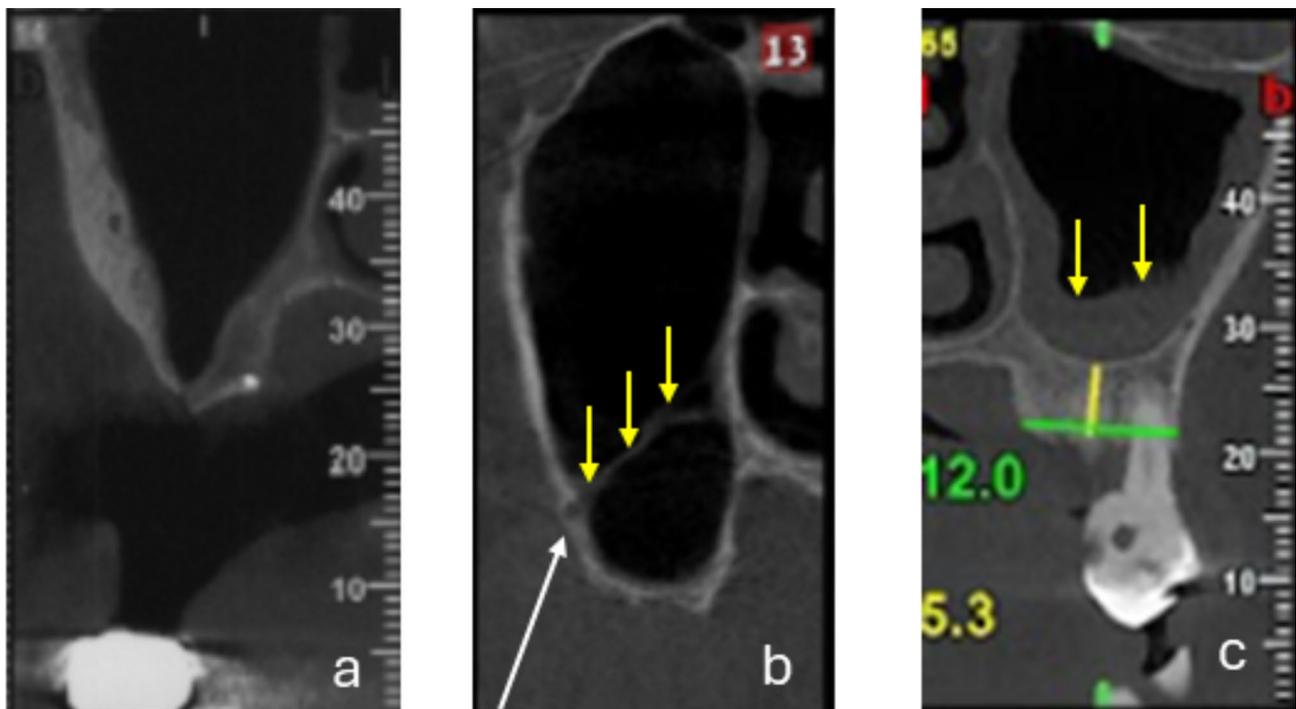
Paraxial CBCT radiographic examinations: a: Triangular shape sinus. b: Oval shape sinus demonstrating a septa (yellow arrows) and a blood vessels (white arrow). c: Round sinus demonstrating a thick SM (yellow arrows)
